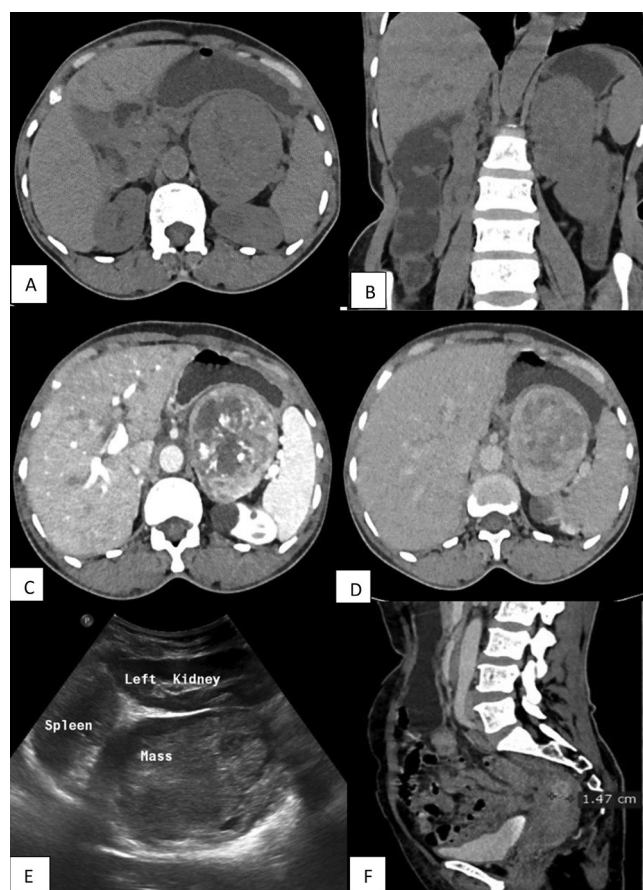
A: Axial unenhanced; B: coronal unenhanced CT images showing large heterogeneous mass lesion in left suprarenal gland. C: Contrast enhanced 1min; D: 15 min delayed scans shows heterogeneous enhancement with nonenhancing areas of necrosis. Persistent enhancement seen in 15min delayed scan. E: Ultrasound image showing the lesion closely abutting spleen and kidney. F: Sagittal contrast enhanced CT images showing endometrial thickening.
